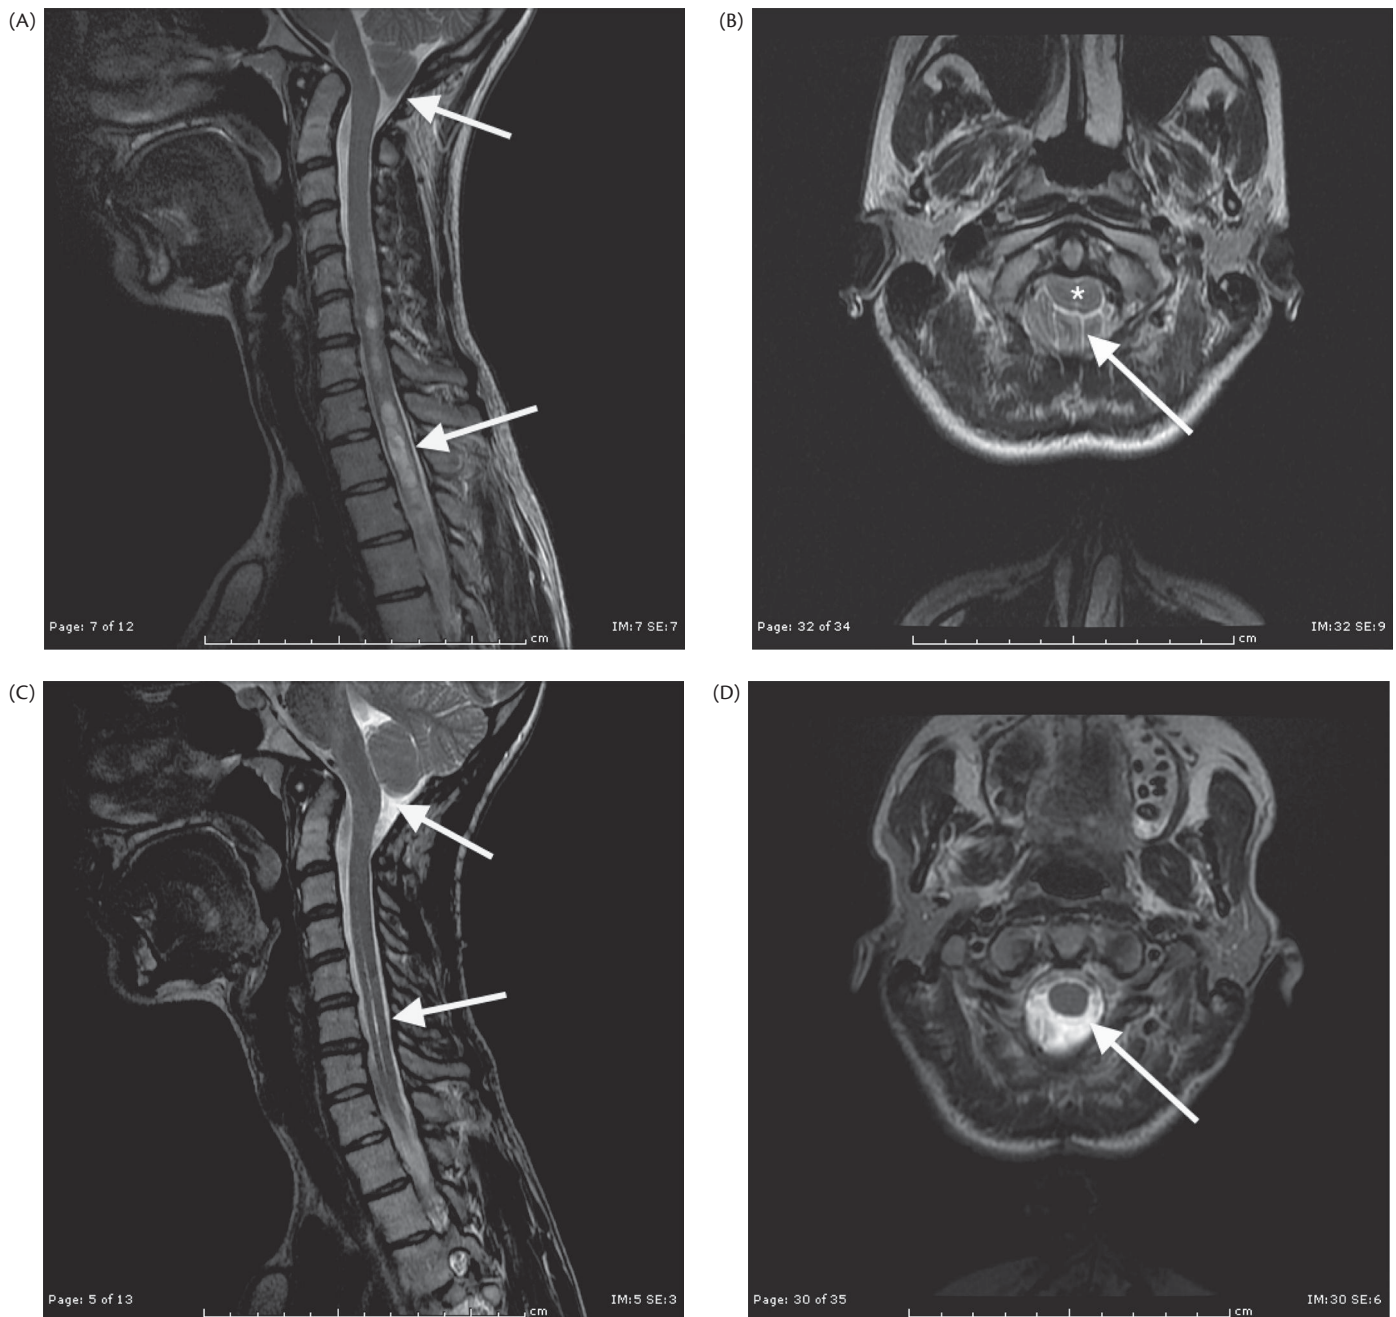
(A) Sagittal T2-weighted MRI of the craniocervical junction showing a Chiari 1 malformation with displacement of the cerebellar tonsils into the foramen magnum (upper arrow) and an extensive cervical syrinx (lower arrow). (B) Axial T2-weighted MRI at the level of C1/2 showing the medulla/spinal cord (asterisk) compressed by the cerebellar tonsils (same patient as Figure 45.3A). (C) Sagittal T2-weighted MRI of the patient in Figure 45.3A,B after surgical posterior fossa decompression with a capacious foramen magnum region (upper arrow) and resolution of the cervical syrinx (lower arrow). (D) Axial T2-weighted MRI of the patient in Figure 45.3 A,B showing the decompressed medulla/spinal cord.
